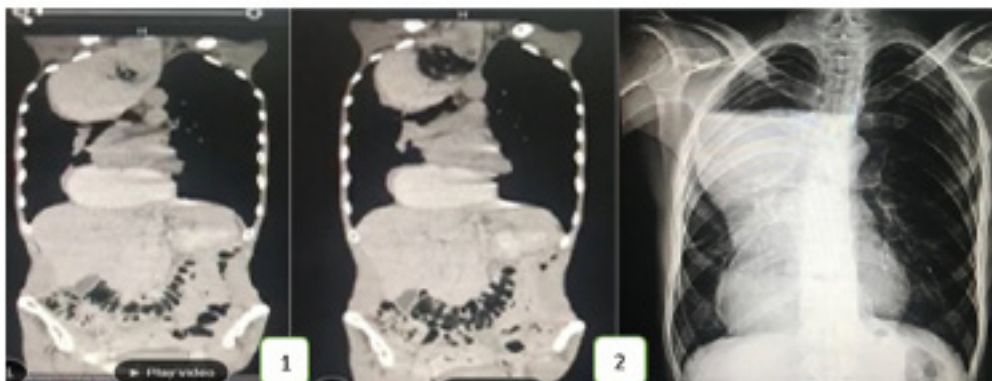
Sagittal CT-scan of the chest show mediastinum and cystic lesion with air fluid level
